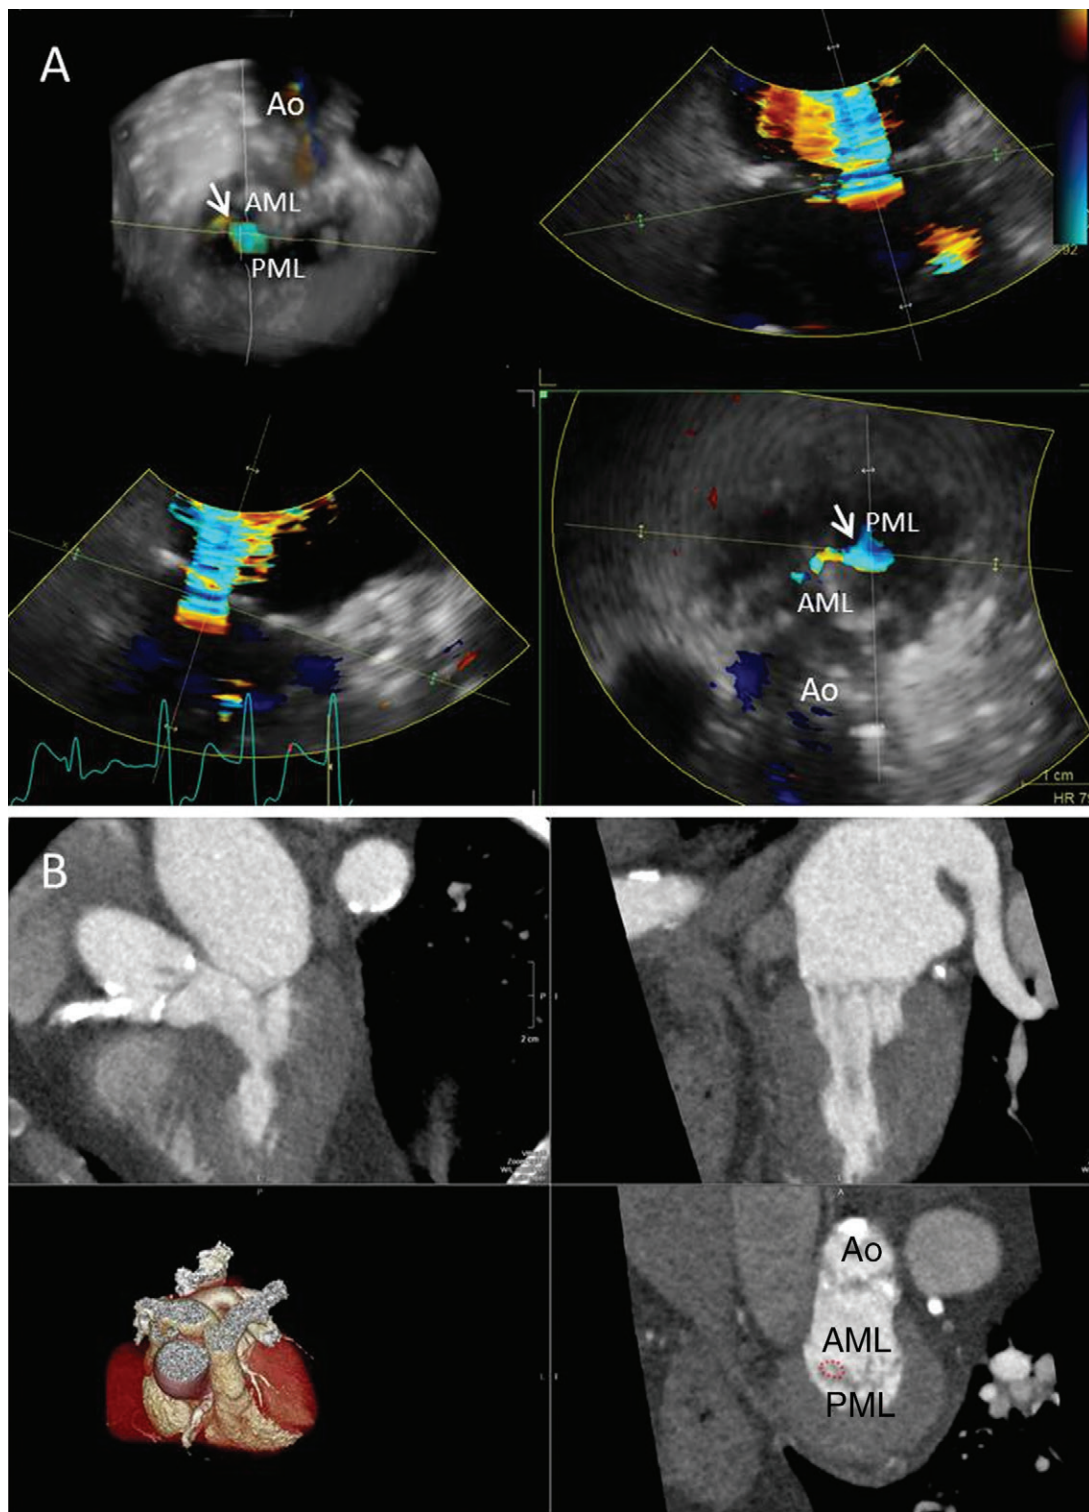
Quantification of mitral regurgitant volume with three-dimensional (3D) imaging techniques in an 87-year-old patient with moderate mitral regurgitation due to lack of medial coaptation (A3–P3, arrow in A, top left image). A, On color Doppler 3D transesophageal echocardiograms, the 3D full-volume data are presented in multiplanar reformation planes oriented across the vena contracta of the regurgitant jet. Arrow = the regurgitant orifice area. B, On multidetector row CT scans, the multiplanar reformation planes are aligned across the mitral leaflet coaptation line. Note the orifice area (red dotted circle) located at the same level (A3–P3). AML = anterior mitral leaflet, Ao = aortic valve, PML = posterior mitral leaflet.
